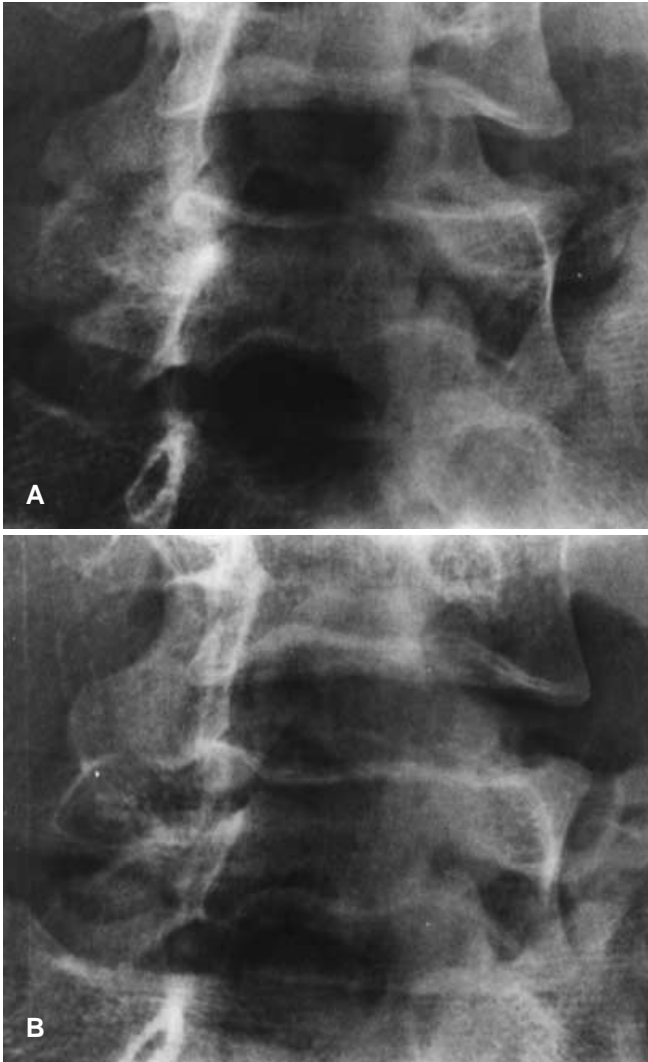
A Preoperative oblique radiograph showing a defect of pars interarticularis. B Oblique radiograph 6 years after direct repair of defect showing a normal appearance of the pars interarticularis
